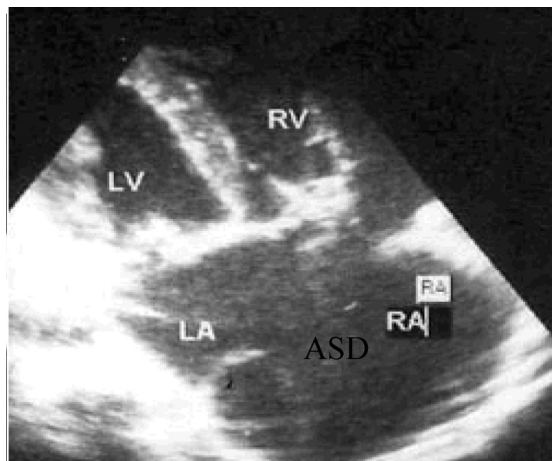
The large atrial septal defect (ASD) on transthoracic echocardiography (apical 4-chamber view). RV indicates right ventricle; LV, left ventricle; LA, left atrium; RA, right atrium.
